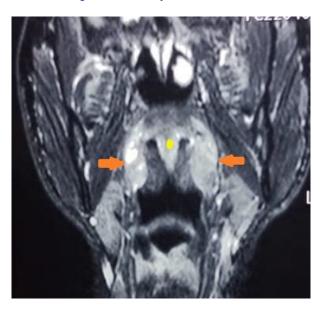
T2/STIR MRI showing hyper-intense cyst in the right tonsillar fossa (orange arrow) and uvula (yellow dot).
